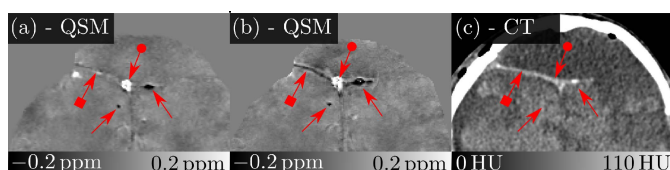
Patient C with posttraumatic evolution of a bifrontal hygroma. The first examination is shown in (a), the second examination, six months later, is shown in (b). Computed tomography (CT; six weeks after injury) confirmed discrete calcification (right straight arrow in (c)). Comparison of (a) and (b) indicates calcification of the dura mater in the follow-up examination.
